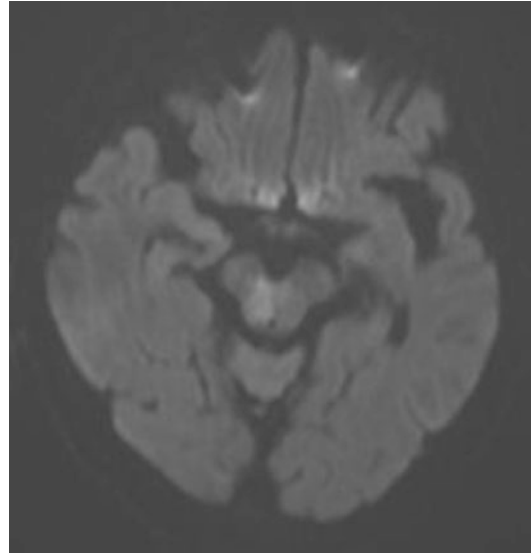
An 81-year-old woman had dizziness, severe dysarthria, bilateral ataxia, and gait difficulty. Diffusion-weighted MRI showed left paramedian infarction in the midbrain. Despite rehabilitation therapy, the symptoms persist, and she was not able to walk alone after 5 years of follow-up
